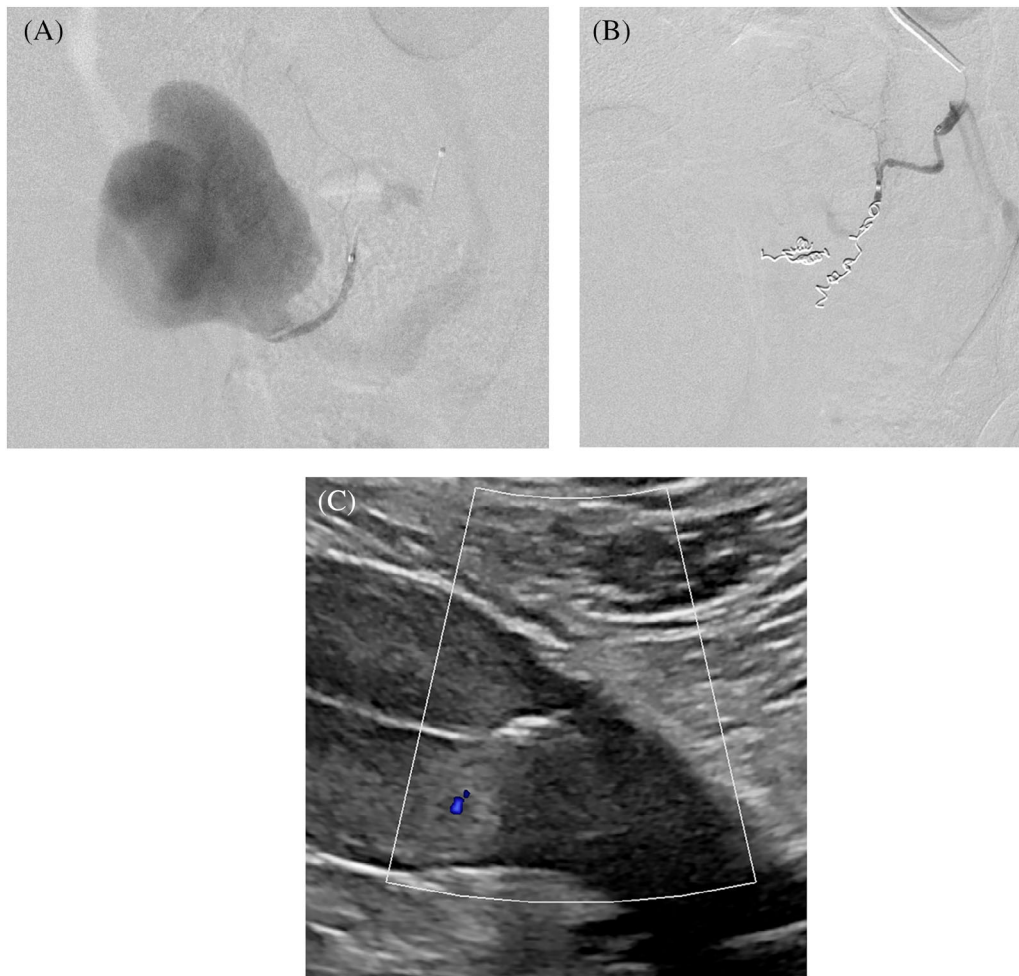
A, Angiographic visualization of uterine pseudoaneurysm with arteriovenous fistula. B, Postembolization angiogram shows the platinum coils. C, Transabdominal sonogram 4 weeks after embolization with no detectable color Doppler signal
